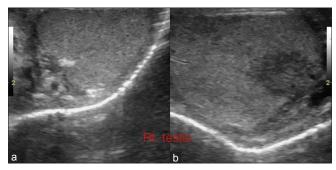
Ultrasonography scrotum: Right testis, oblique (a) and axial (b) sections show heterogeneously enlarged testis with a hypoechoic lesion in the head containing septa. Possibility of infective pathology likely
